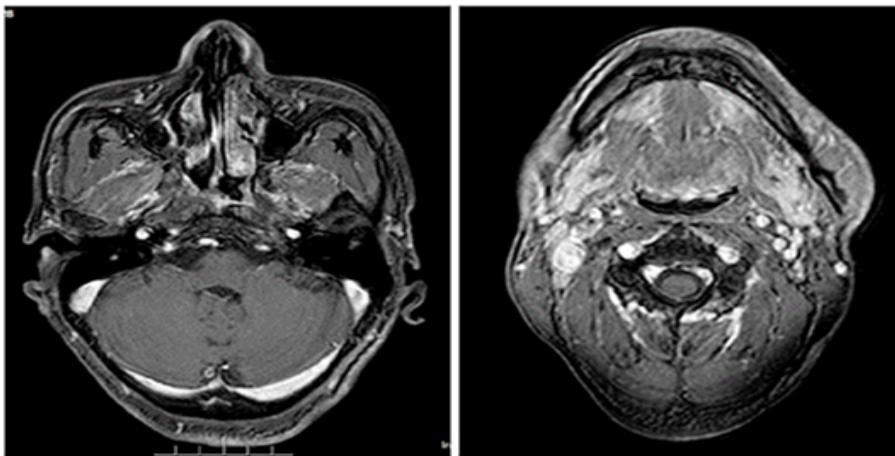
MRI images of the nasopharyngeal mass(left) and neck lymph nodes(right) before concurrent chemoradiotherapy.
